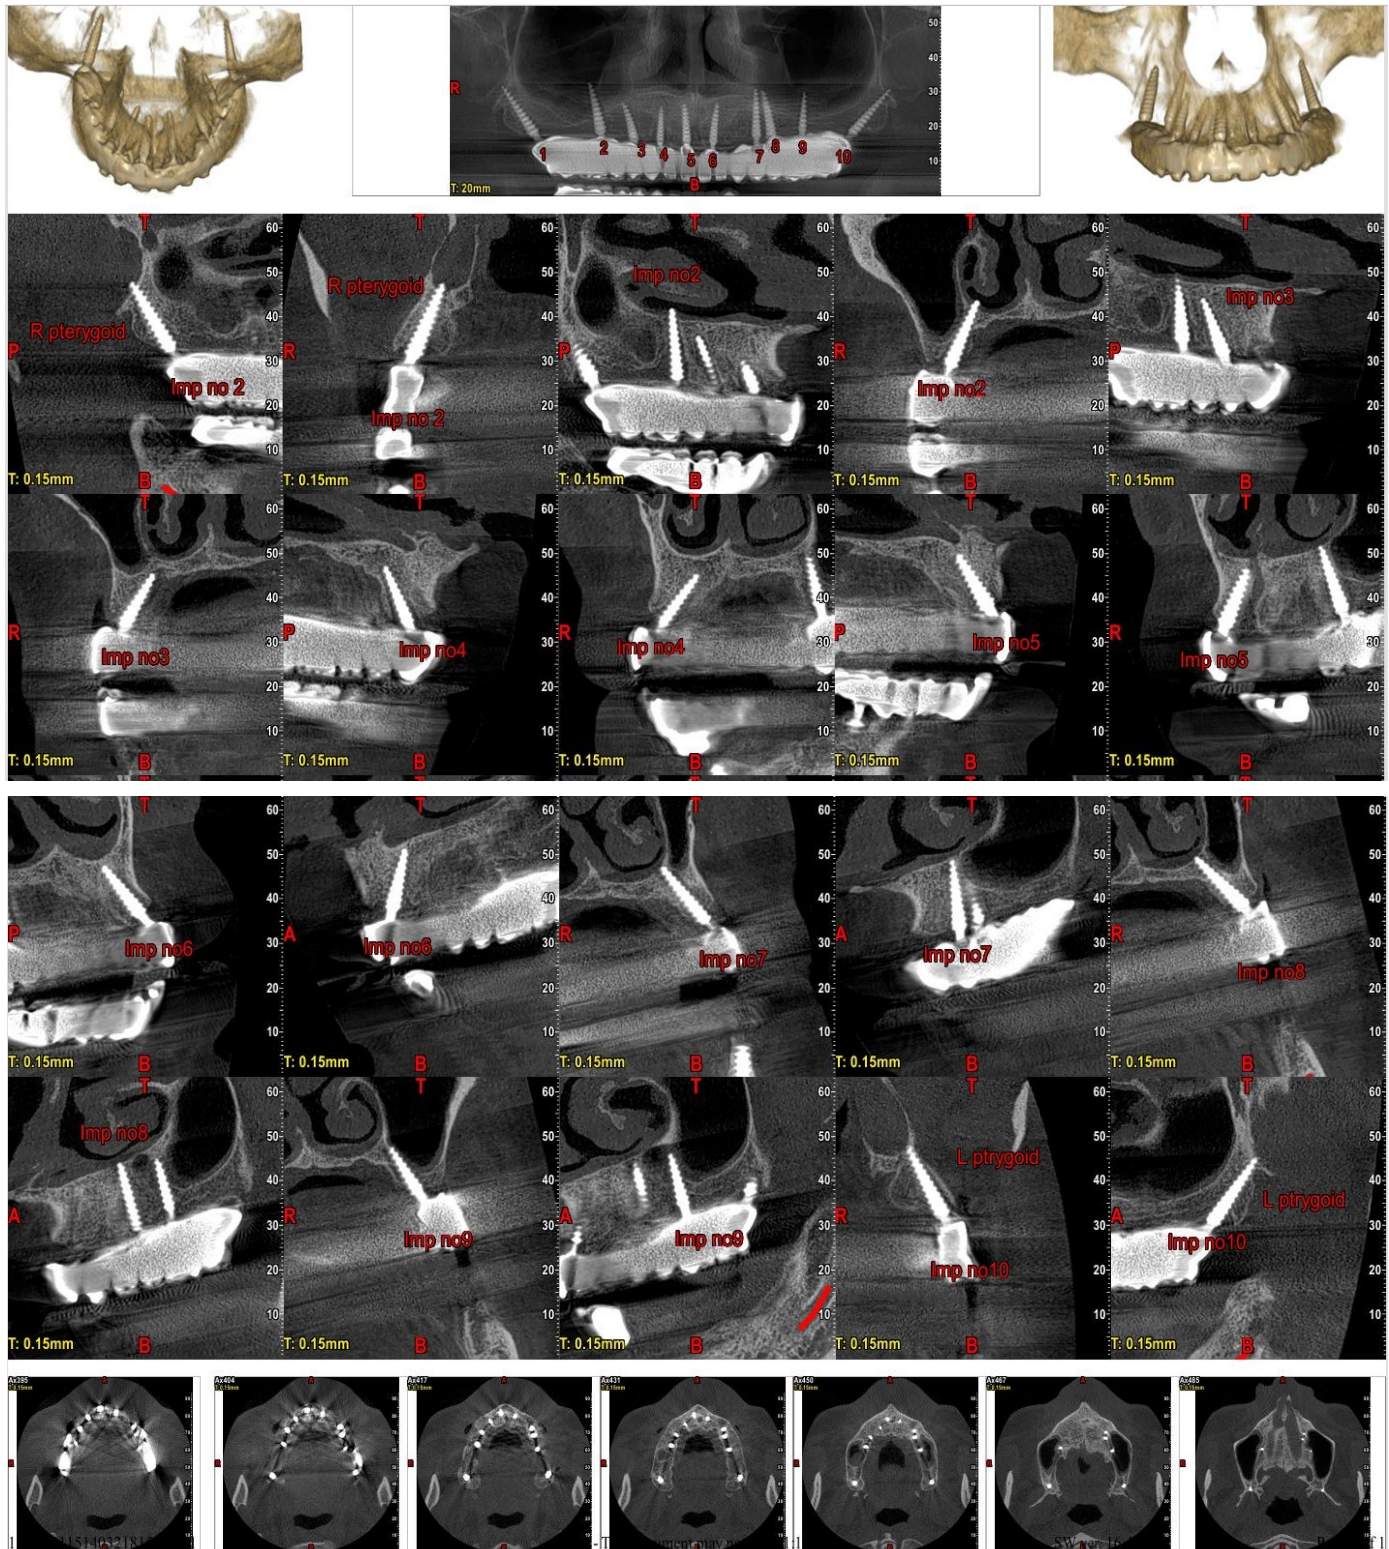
CBCT view of full arch case treated with compressive implants and bilateral pterygoid implants
